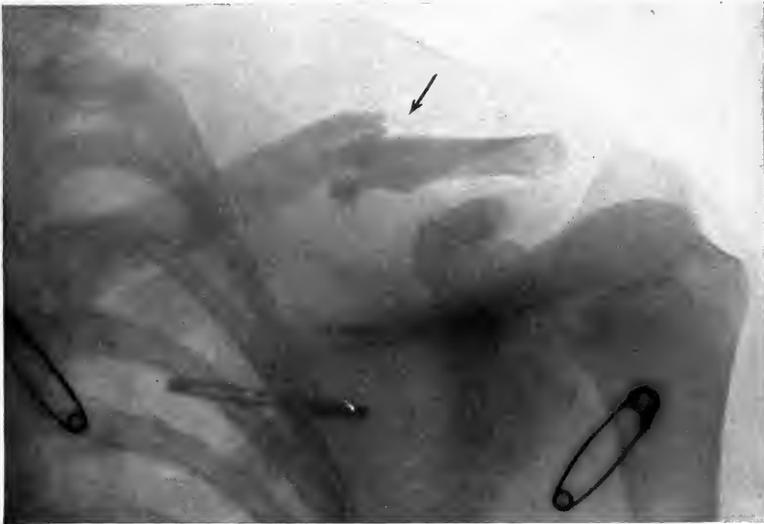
X-RAY OF FRACTURE OF CLAVICLE IN BOY OF EIGHTEEN.
